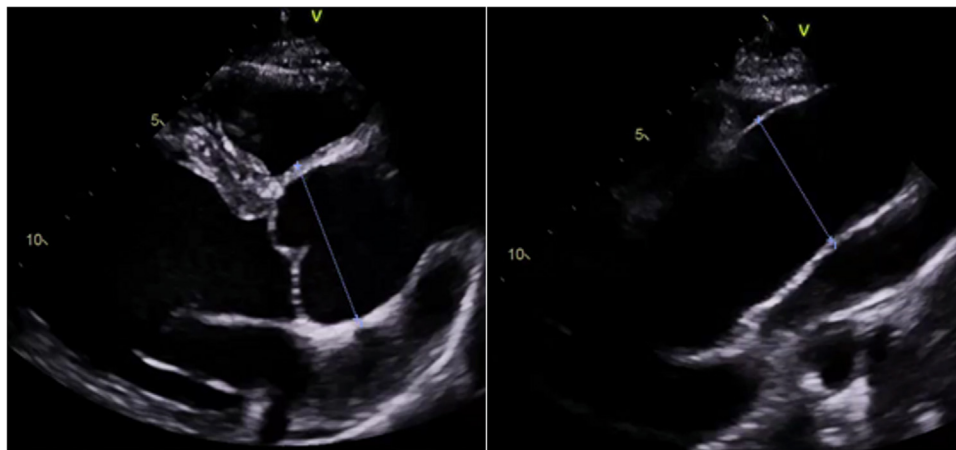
Short-Axis Transthoracic Echocardiogram View
